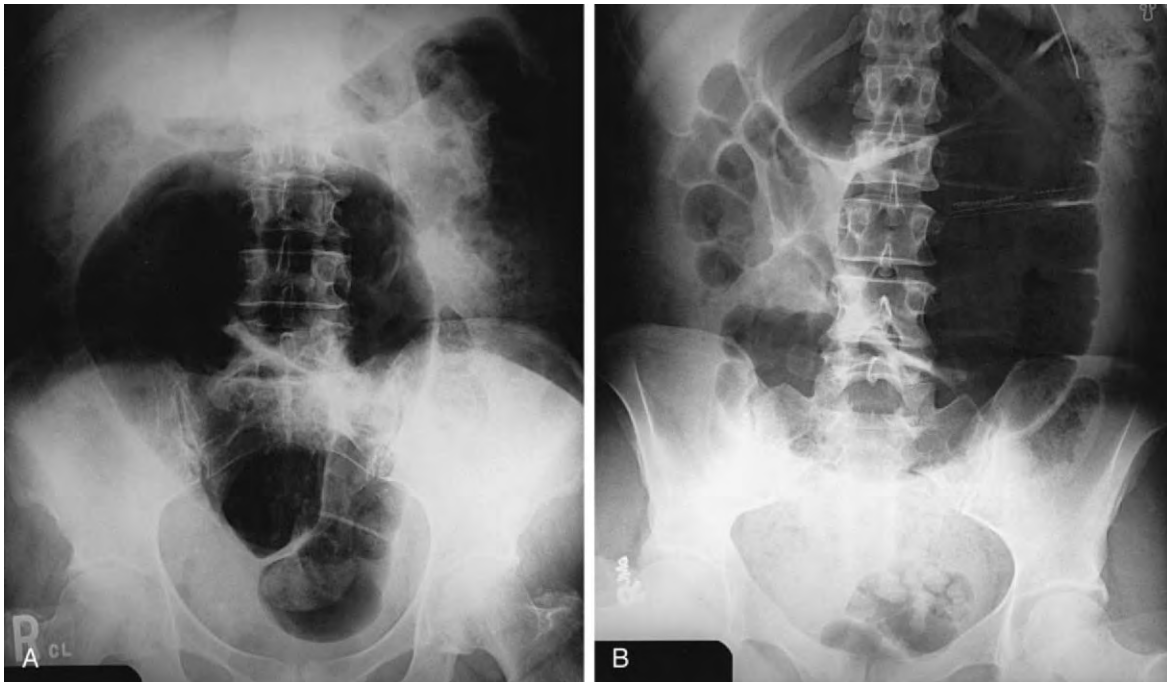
A, Plain abdominal radiograph of a sigmoid volvulus with the “bent inner tube” sign. The colon is the shape of a coffee bean, with proximal fecal impaction. B, Plain radiograph of a cecal volvulus with the kidney bean–shaped rotated ileocecal region and proximal small bowel obstruction.
